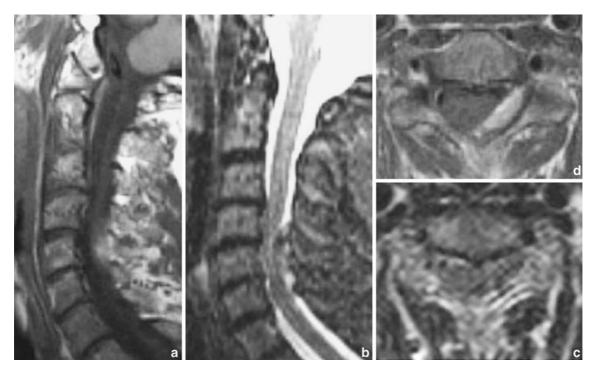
MRI performed 7 days later. The haematoma is smaller nevertheless it is located at the same C4-C5 level
